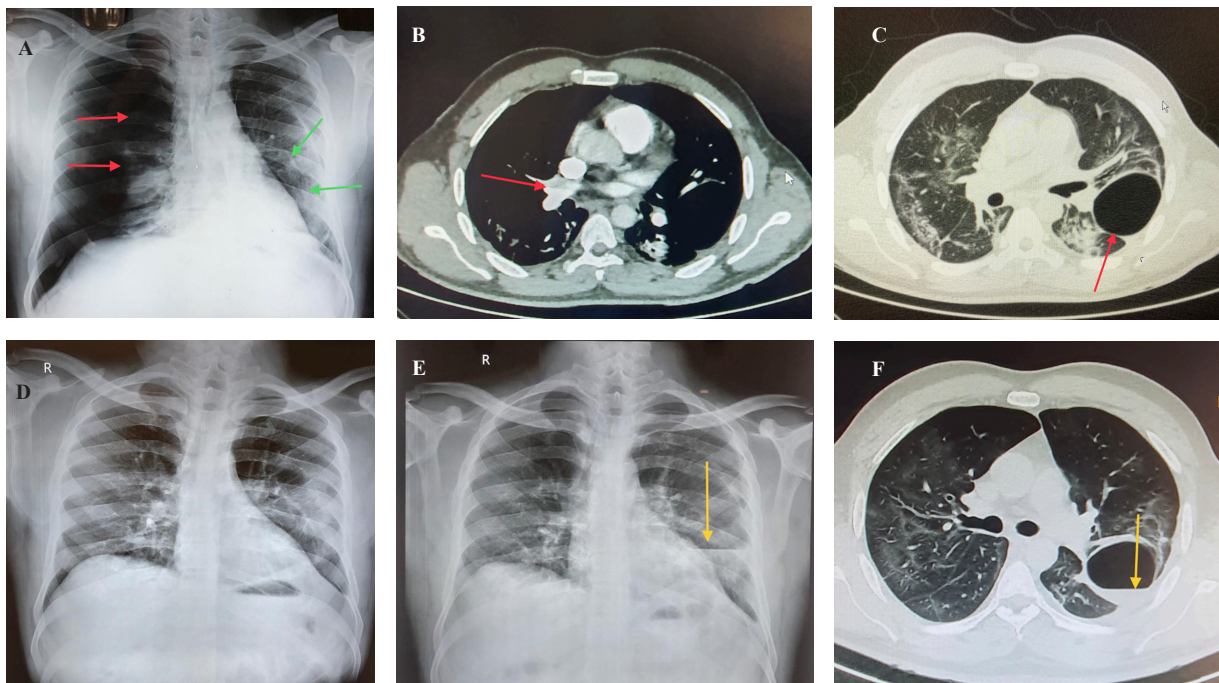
Chest X-ray showing a right-sided pneumothorax (red arrows showing collapsed lung border) and a large left-sided pneumatocele (green arrows showing pneumatocele borders) (A). CT pulmonary angiography done on first hospitalization with us (8 weeks post-COVID) showing thrombus in the right upper lobar pulmonary artery (red arrow) and the segmental arteries of an apical-posterior segment of the right upper lobe (B). High-resolution CT thorax done on first hospitalization with us (8 weeks post-COVID) showing diffuse resolving ground-glass opacities with interlobular septal thickening in both lungs and a large pneumatocele in the left lower lobe (red arrow) (C). Chest X-ray after intercostal tube drainage removal showing complete lung expansion and successful resolution of the pneumothorax (D). Chest X-ray (E) and high-resolution CT thorax showing a left-sided infected pneumatocele with a fluid level at the time of re-hospitalization (yellow arrows) (F).
